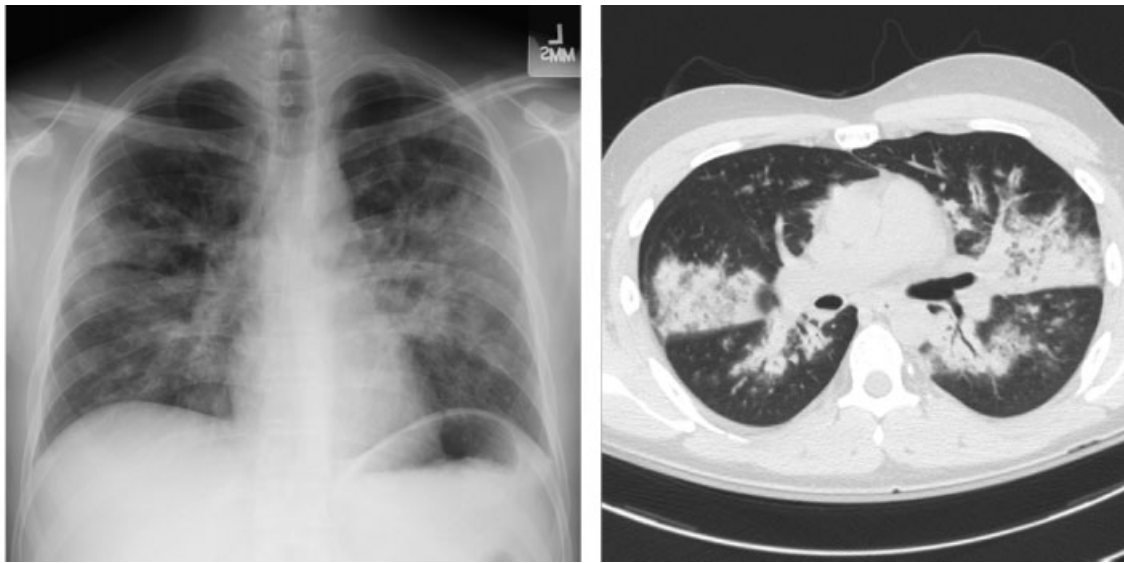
(A) Chest x-ray and (B) computed tomographic scan from a 24-year-old male patient with active Wegener granulomatosis and alveolar hemorrhage, showing bilateral alveolar infiltrates. In addition, there is significant peribronchial inflammation. (Reproduced with permission from Dr. Ulrich Specks.)
